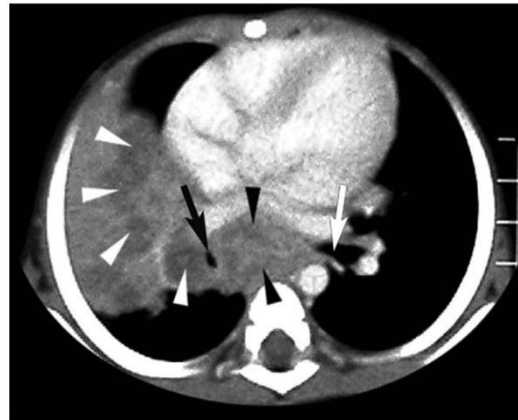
Same patient as in Fig. 1 – CT shows BI (black arrow) and LMB (white arrow) stenosis with extensive 'ghost-like' enhancing subcarinal, precarinal (black arrowheads) and R hilar (white arrowheads) lymphadenopathy, with RUL consolidation.
